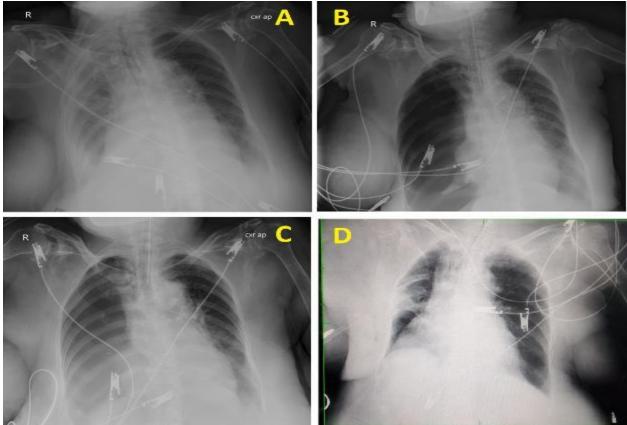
Chest X-ray views of female patient 92 years old presented with sudden dyspnea after choking after ingestion of antibiotic tablet. A- CXR when presented showing reduced Rt side volume with ipsilateral mediastinal displacement, B- Post ventilation Rt pneumothorax, C- Follow up with the same finding, D- After insertion of an intercostal
